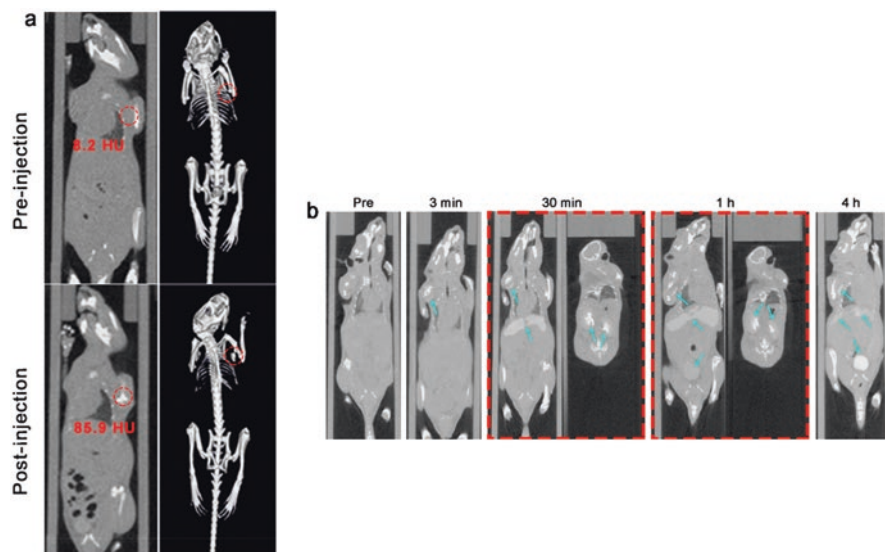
Representative images of in vivo CT images (a) pre- and posttreatment with $\text{Au}_1\text{Bi}_1\text{-SR}$ NPs injected intratumorally (b) pre- and posttreatment with $\text{Au}_1\text{Bi}_1\text{-SR}$ NPs at different time intervals. (Image adapted from Ref. [43])
